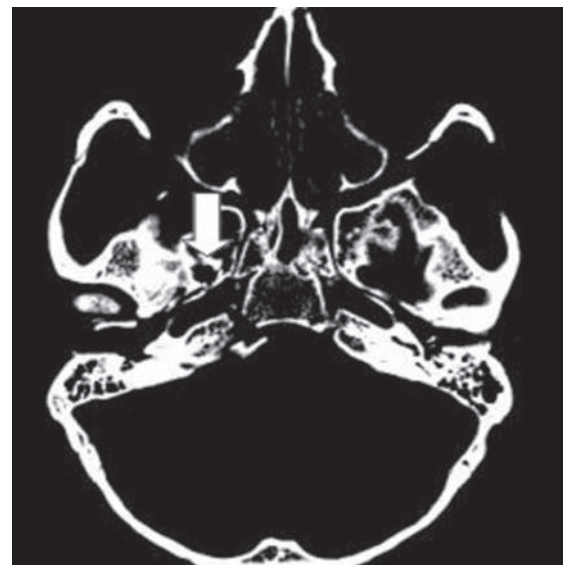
CT scan showing fracture involving the right foramen ovale (block arrow)
